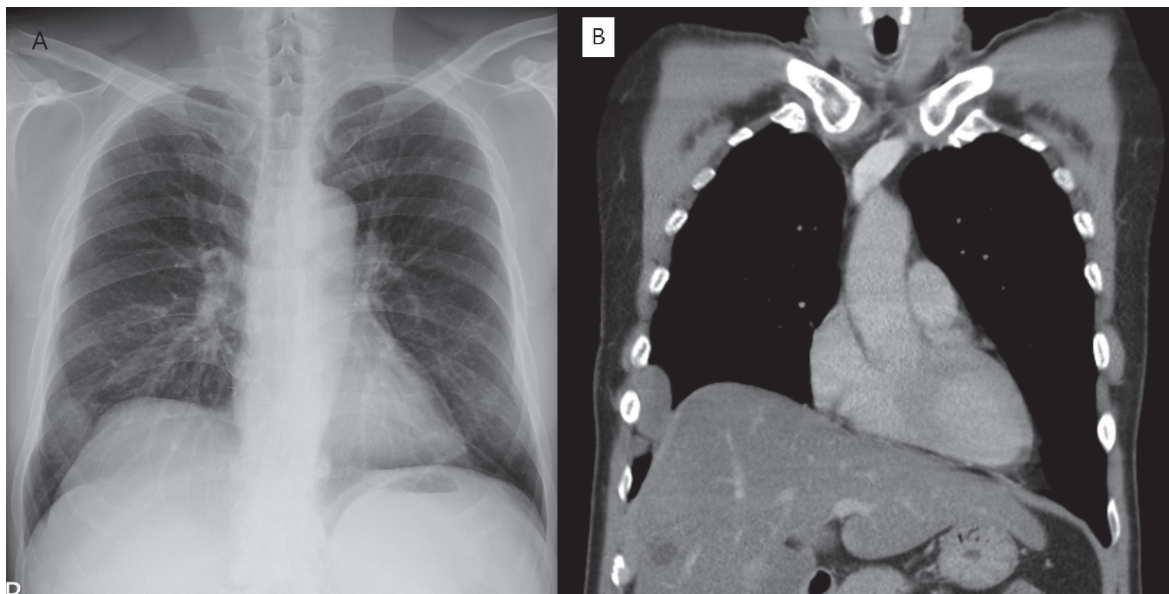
(A) Six years after surgical resection, chest radiography revealed a nodular opacity at the right lower lung field. (B) A chest computed tomography coronal view showed a tumor lesion at the right anterior lower lung region. Recurrent solitary fibrous tumor of the pleura was suspected.
